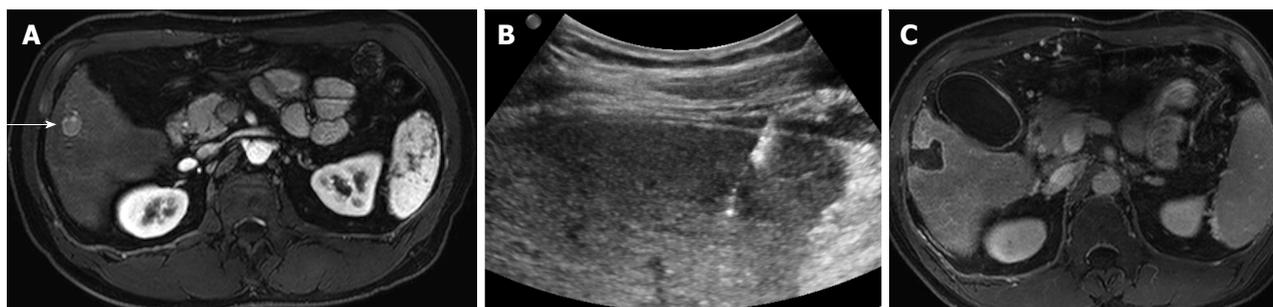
Radiofrequency ablation of a focal hepatocellular carcinoma. A: Contrast-enhanced MR of a 60-year-old male with cirrhosis demonstrates a single hepatocellular carcinoma in the right hepatic lobe (arrow); B: Ultrasound demonstrates a radiofrequency probe coursing through the hypoechoic tumor; C: Contrast-enhanced MR 1 mo after radio-frequency ablation demonstrates a large ablation defect, without any residual enhancement to suggest viable tumor. MR: Magnetic resonance.
